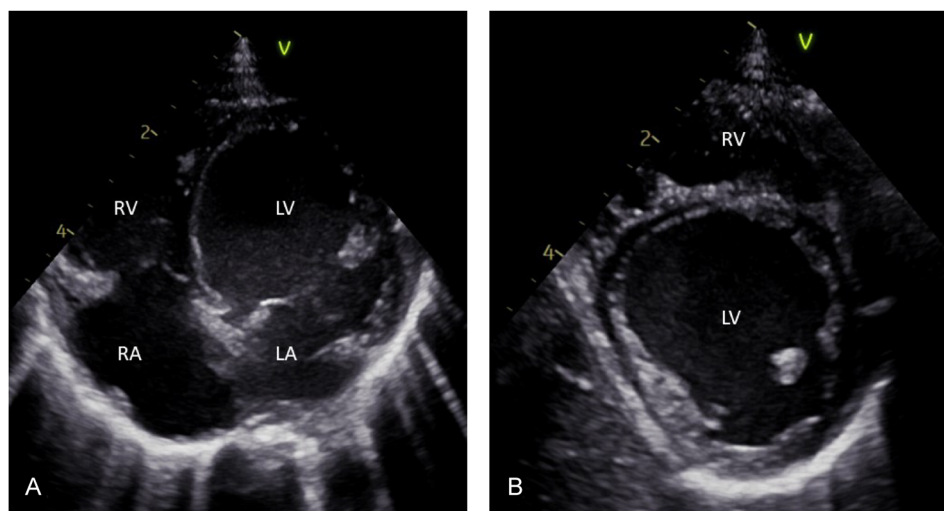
Transthoracic echocardiography in chronic lymphocytic myocarditis with the phenotype of dilated cardiomyopathy and acute heart failure
